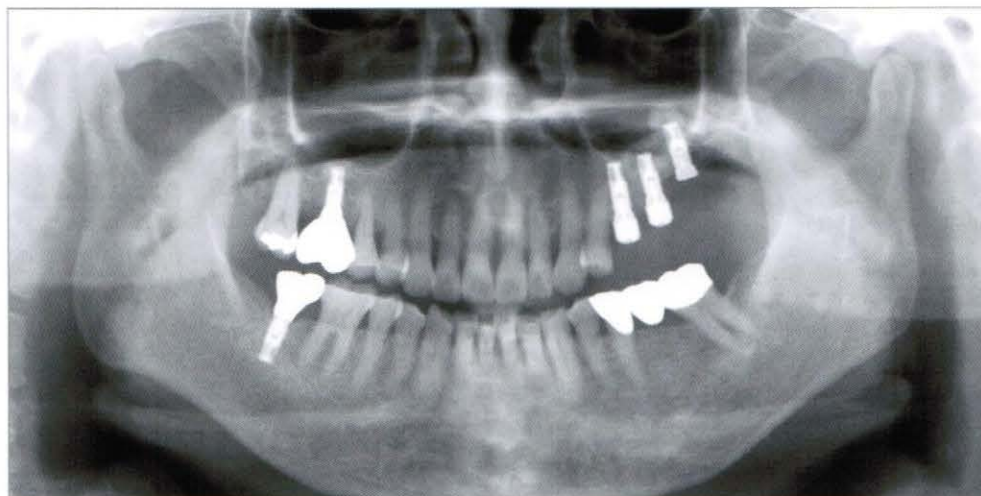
Panoramic radiograph after placement of crown on the lower right second molar (2006, 3,21)
